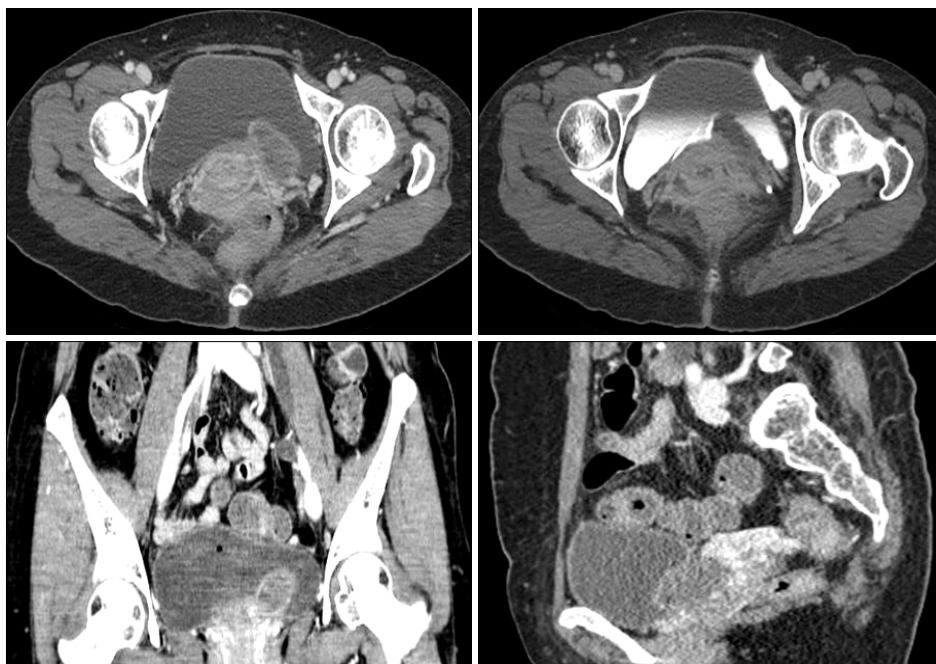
Follow-up computed tomography (CT) scan of the bladder shows 4cm mass along the distal ureter and bladder cuff. Axial and coronal contrast-enhanced CT images show the mass enhanced lesion along the left distal ureter and ureterovesical junction. Axial and coronal CT image at the excretory phase shows ureteral mass protruding into the bladder as filling defect.
